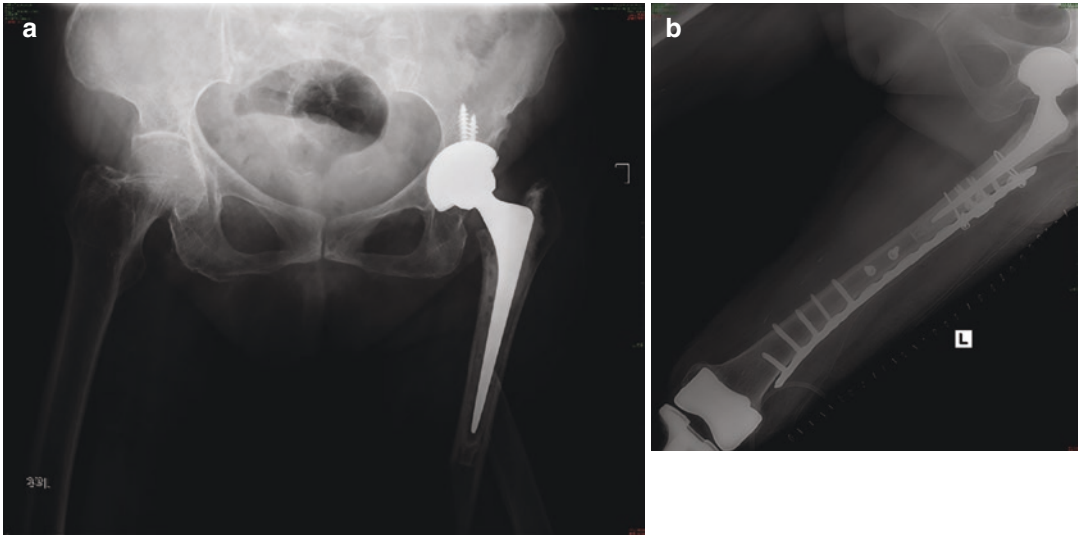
Radiograph of a periprosthetic femoral fracture type D between the proximal and distal components after total hip and knee arthroplasty. (a) Preoperative image. (b) This patient was treated by open reduction and internal fixation
